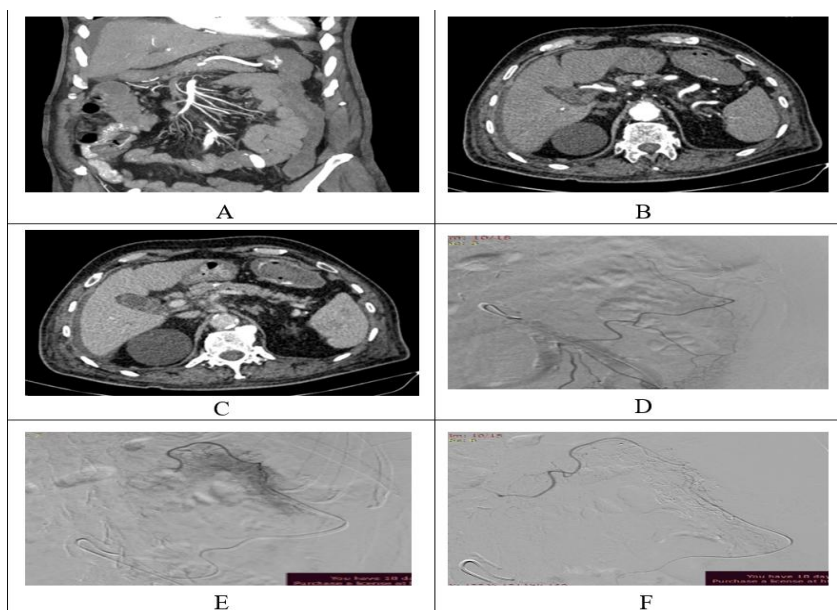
Angiodysplasia of splenic flexure.(A-G) CT angiography (CTA) and digital subtraction angiography (DSA) of an 80-year-old male patient presented with hematochezia (A-C) CTA
